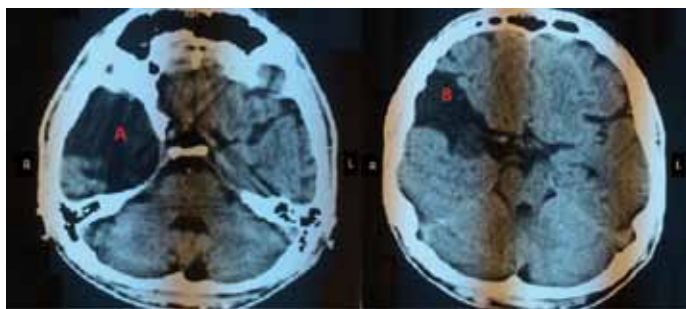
Spiral CT scan of the patient's brain dated 10.06.2010, cyst of the pole of right temporal lobe and Sylvian fissure. A – cyst of the pole of right temporal lobe; B – cyst of the right Sylvian fissure
